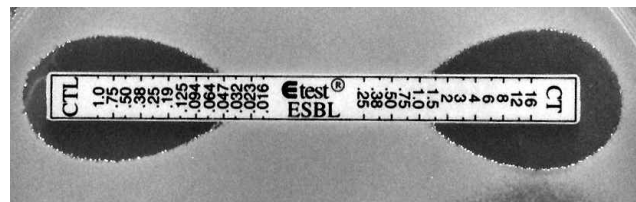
Clear-cut ESBL positive: MIC CT/CTL = 1.5/0.047 = 32.
